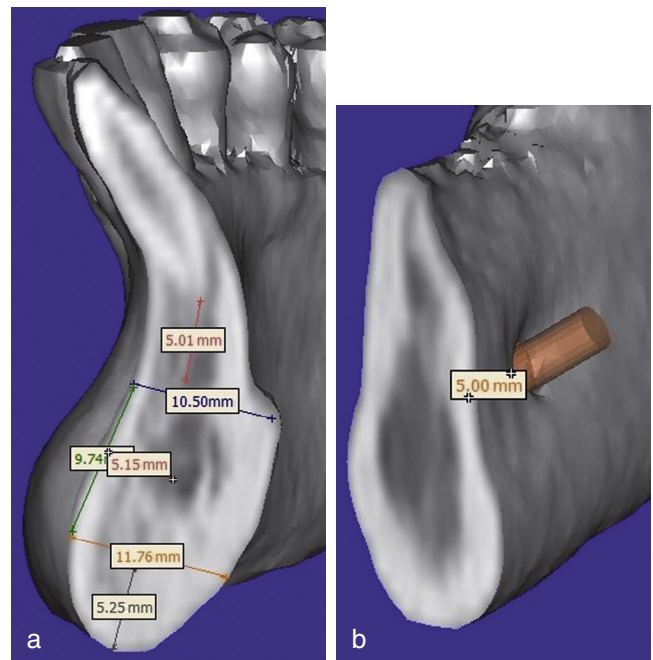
(a, b) Proceeding from a three-dimensional CT image, with implant planning software (SimPlant A, Materialise NV, Leuven, Belgium) it is possible to make sections (clipping) on oblique sagittal planes at any point in the image and perform any measurement. Here we see the Rule of 5s rule applied to the section. Measurements indicate 5-mm distance from the dental apices, 5 mm from the mandibular edge, and in b, 5 mm from the mental foramen. Keeping this safe distance it is possible to harvest a block, approximately 1 cm high and 5 mm thick, without going too deep. The Rule of 5s is a general rule and has little value when the procedure can be performed directly and the presence of the anatomic obstacles can be evaluated.
